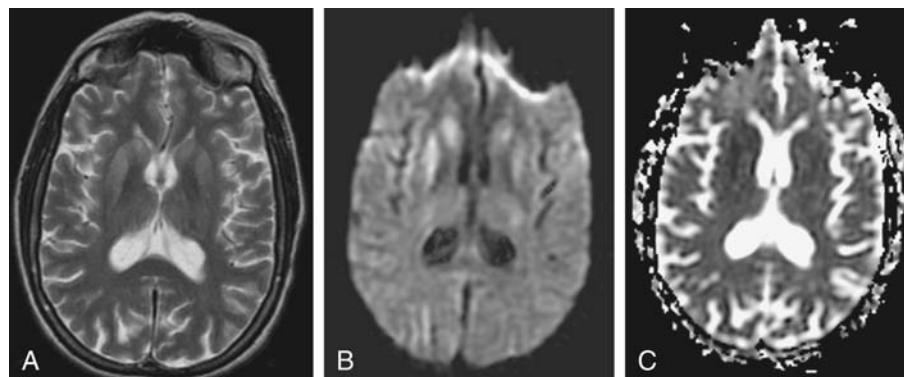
Sporadic Creutzfeldt-Jakob disease in a 34-year-old male, who presented with abnormal leg movement and slowness of thinking. (A) Axial T2-weighted MR image shows an area of subtle abnormal signal hyperintensity in the right putamen and caudate nuclei. (B) Axial diffusion-weighted images show bilateral areas of abnormal high signal intensity at the putamen and caudate nuclei, particularly in the right. (C) Axial ADC map from diffusion-weighted imaging demonstrates reduced ADC value. Abbreviations: MR, magnetic resonance; ADC, apparent diffusion coefficient.
